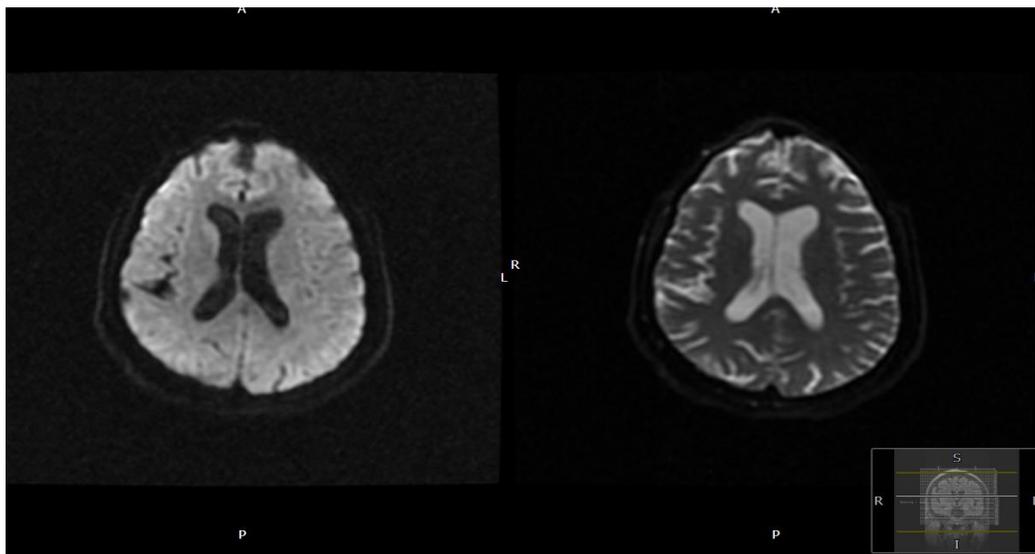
MRI head 2 days after admission. Small vessels disease only, No tuberculoma.
